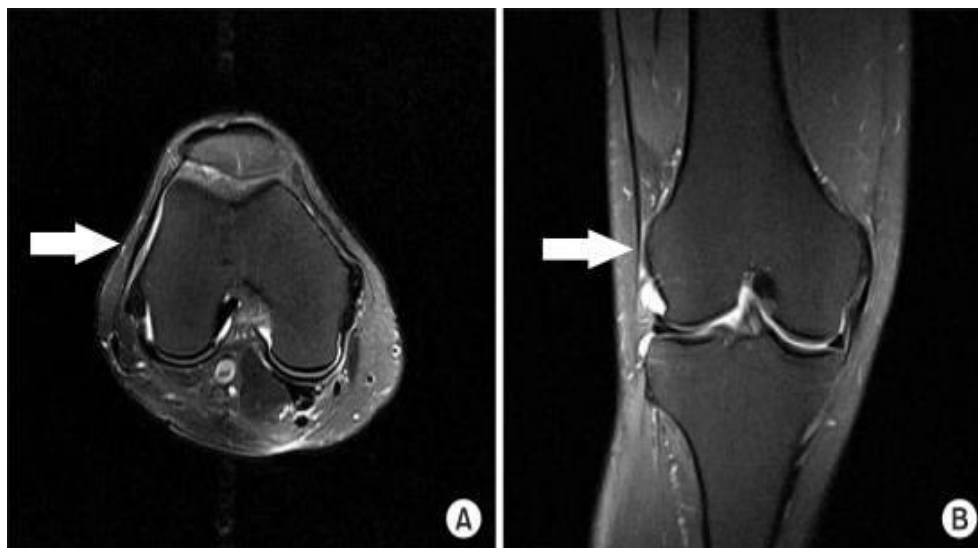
Pictured is an MRI of an ITBS patient with increased signal (inflammation). Inflammation beneath the ITB (black stripe by pointer of arrow) is observed, but not on the actual ITB itself. Adapted from Hong and Kim 2013
